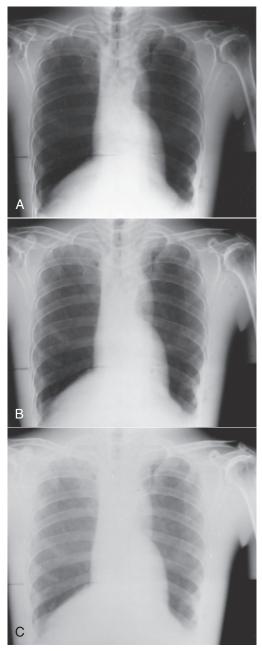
Normal chest radiograph taken at 70 kVp (B). If the kilovoltage is increased by 15% to 80 kVp (A), overexposure occurs. Similarly, at 15% less, 60 kVp (C), the radiograph is underexposed. (Courtesy Euclid Seeram, British Columbia Institute of Technology.)
